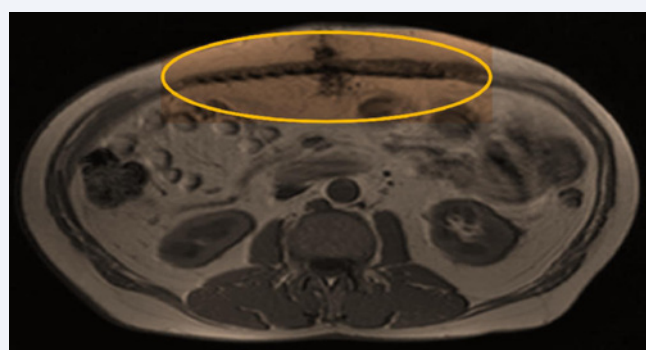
Magnetic resonance image (MRI) of DynaMesh®-CICAT visible in a patient one year after Rives-Stoppa repair with component separation. The hypo-intense “visible” filaments are clearly distinguishable from the surrounding tissues in the abdominal wall. The mesh follows the contour of the abdominal wall without visible folds, consequently there is no or minimal mesh shrinkage.
